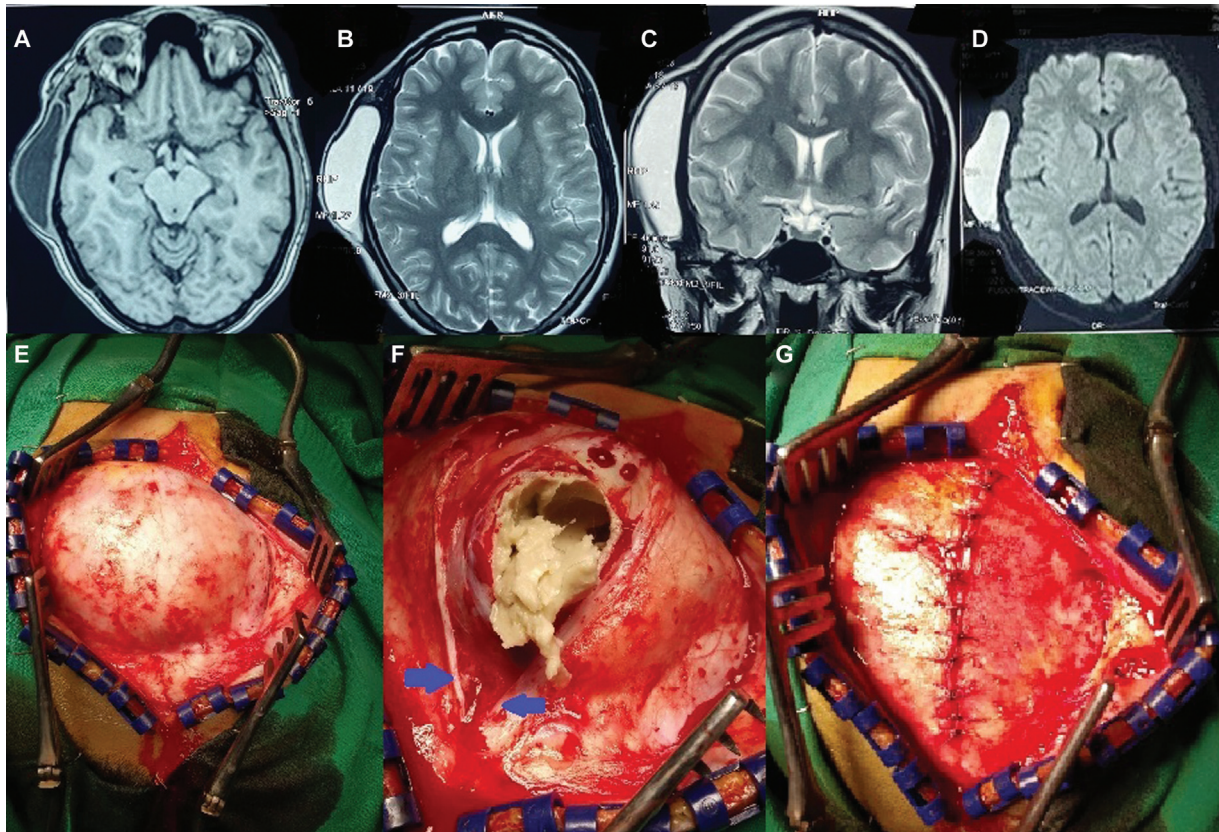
Magnetic resonance imaging showing an encapsulated well-defined lesion, with no intracranial extension in right temporalis muscle (A). The lesion is hypointense to the muscle on T1 sequences and hyperintense to the muscle on T2 axial (B) and coronal images (C). It shows diffusion restriction on diffusion-weighted imaging sequences (D). Intraoperative images showing (E) lesion to be beneath the temporalis fascia; (F) cheesy material and hair seen after the capsule is opened while piecemeal removal is carried out. The cut edges of the temporalis muscle are shown (blue arrows); and (G) temporalis fascia resutured after complete removal of lesion with capsule.
